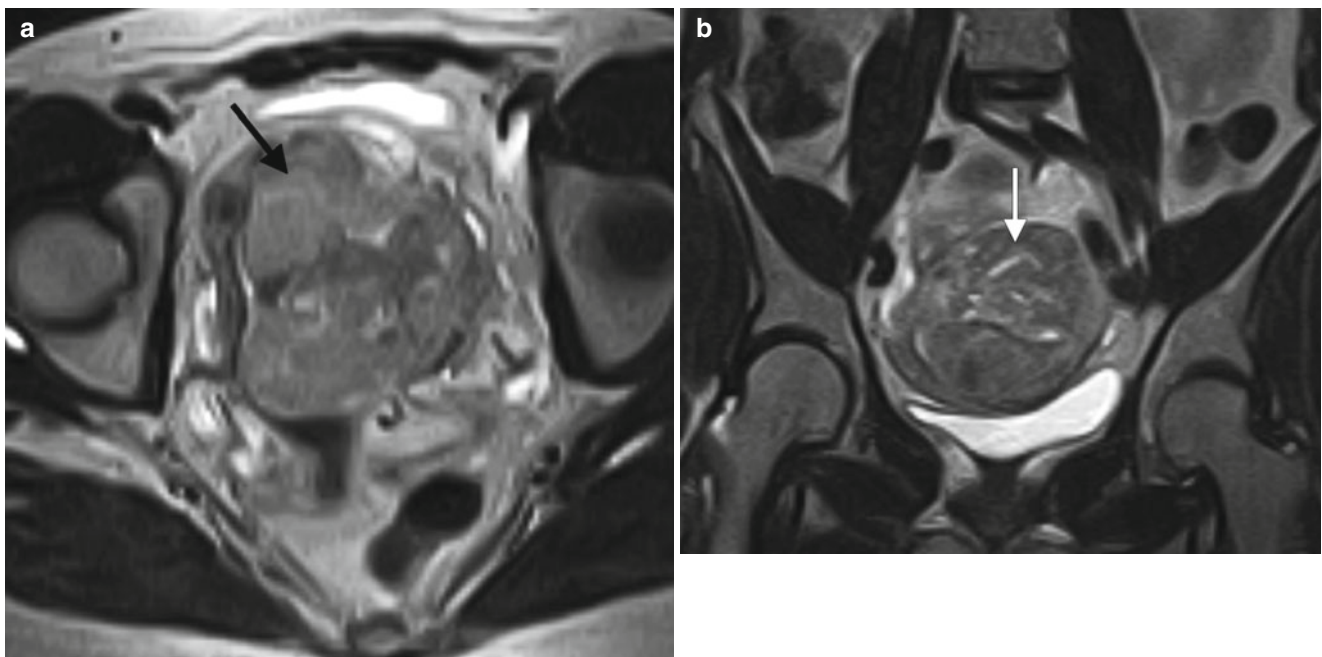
High-grade epithelioid leiomyosarcoma in a 53-year-old woman with pelvic pain. Axial (a) and coronal (b) T2-weighted MR images, an axial fat-suppressed T1-weighted image following intravenous
